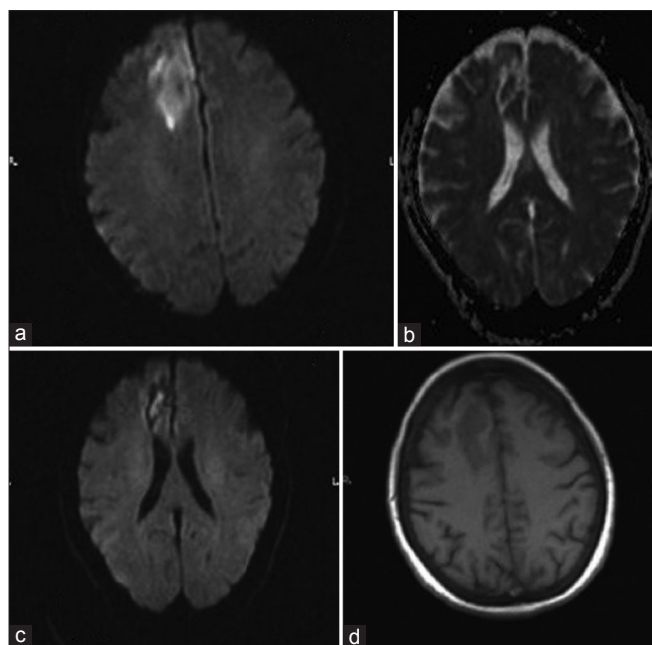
(a) DWI (diffusion-weighted imaging) (b-value: 1,000): High signal of the lesion (diffusion is restricted) (b) ADC (apparent diffusion coefficient) values show a limited diffusion (values ranging between 0.45 and $0.65 \text{ mm}^2/\text{s} \cdot 10^{-3}$) (c) Same patient, 6 weeks later: DWI (b-value: 1,000): High signal of the central part of the lesion (target sign) (d) Same patient, 6 weeks later: ADC values show an increased diffusion (values ranging between 1.12 and $1.2 \text{ mm}^2/\text{s} \cdot 10^{-3}$)
